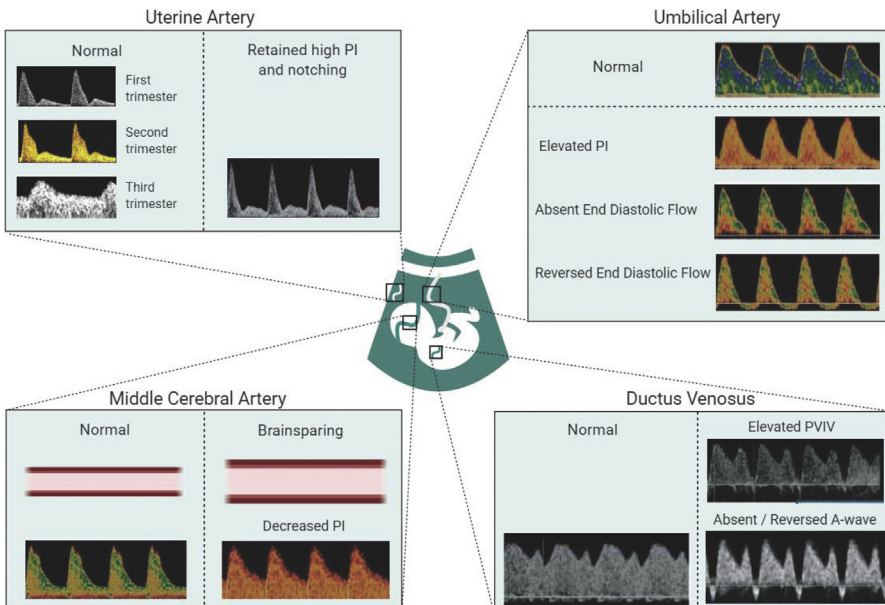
Different Doppler flow patterns in maternal and fetal vessels relevant to placental function. PVIV, peak velocity index for the vein.
